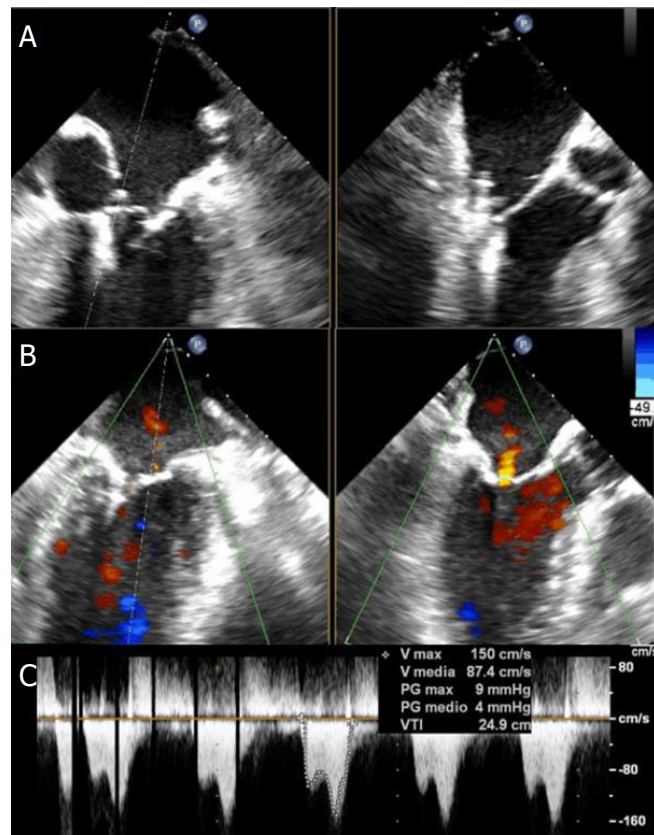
Intraprocedural trans-esophageal echocardiogram of NTR clip implantation: A2-P2 grasping (A), residual minimal mitral regurgitation (B) and transmitral gradients (C)
